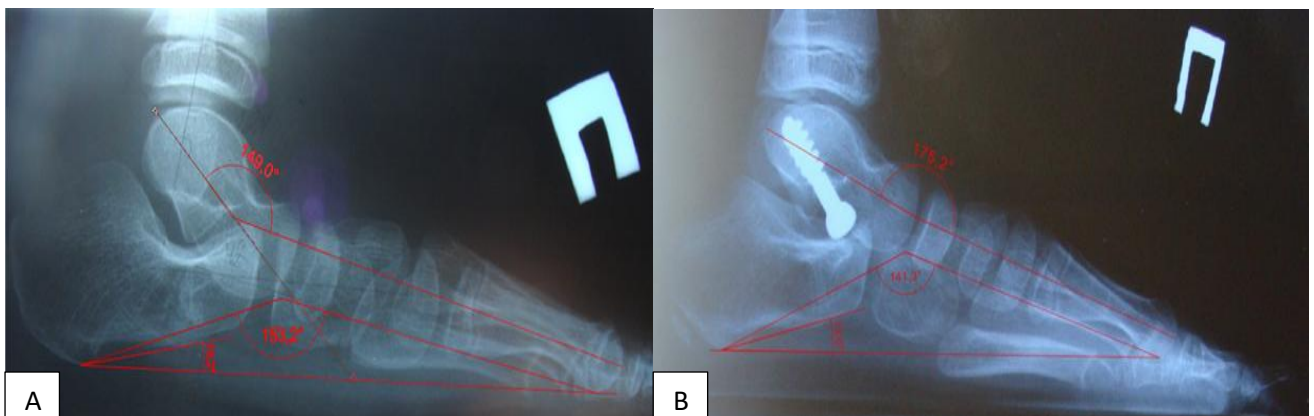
(A and B): Preoperative radiographs of patient N. (8-year-old). A-Seen absence of the longitudinal arch. B-Postoperative photograph of the same patient 1 year after operation, present correction of the longitudinal arch.
